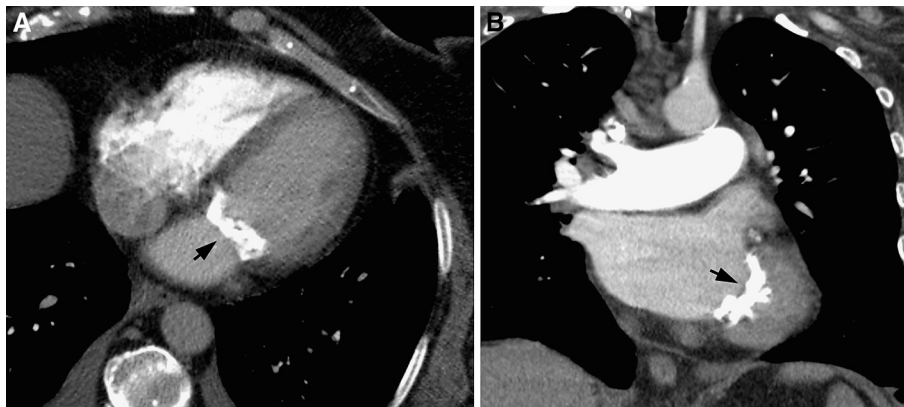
A 52-year-old woman admitted with sudden onset dyspnea and pleuritic chest pain. Computed tomography (CT) pulmonary angiography was performed to exclude pulmonary emboli. Axial (A) and coronal (B) CT images, showing heavy calcification of the mitral valve leaflets and annulus (arrows), which suggests underlying mitral stenosis. Heavy or heterotopic mitral annular calcification can be mistaken for a mass on echocardiography or magnetic resonance imaging, and CT can be the best modality to depict heavy valvular calcification.
